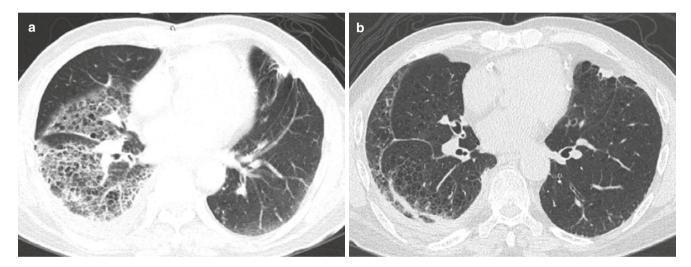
Emphysema with pneumonia is often mistaken for cystic lung disease. (a) Initial CT image shows multiple small lucencies in the right lung with walls. Note mild emphysema in the left lung. (b) Follow-up
